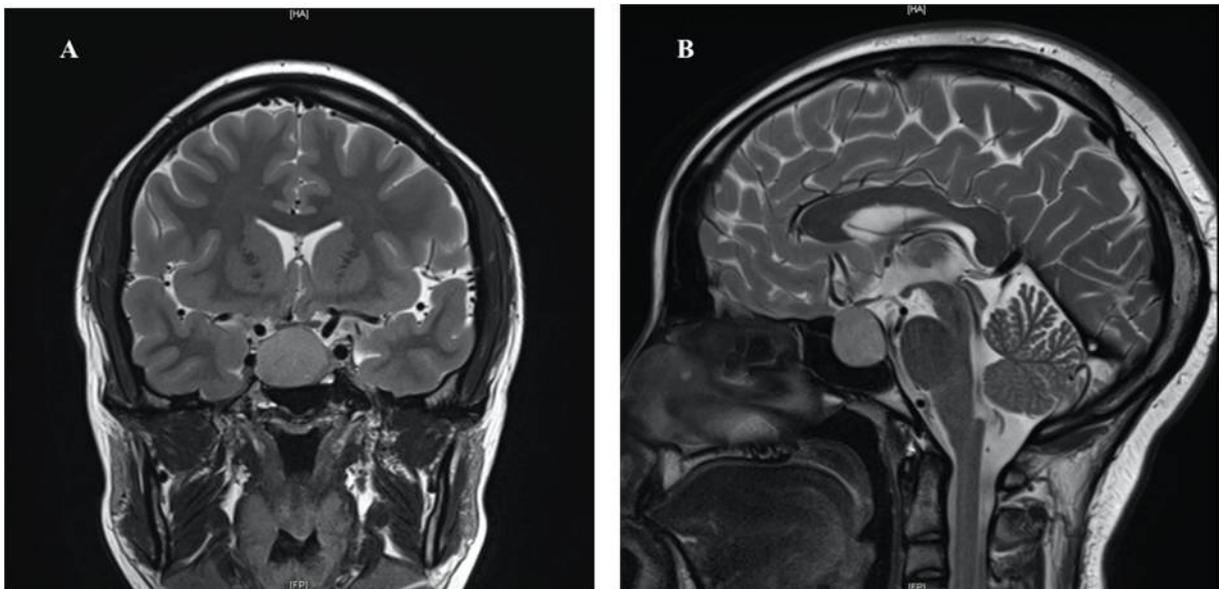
FSH-secreting pituitary adenoma. T2-weighted coronal (A) and sagittal (B) MRI revealing an intra-sellar tumor measuring 18 x 22 x 21 mm.
